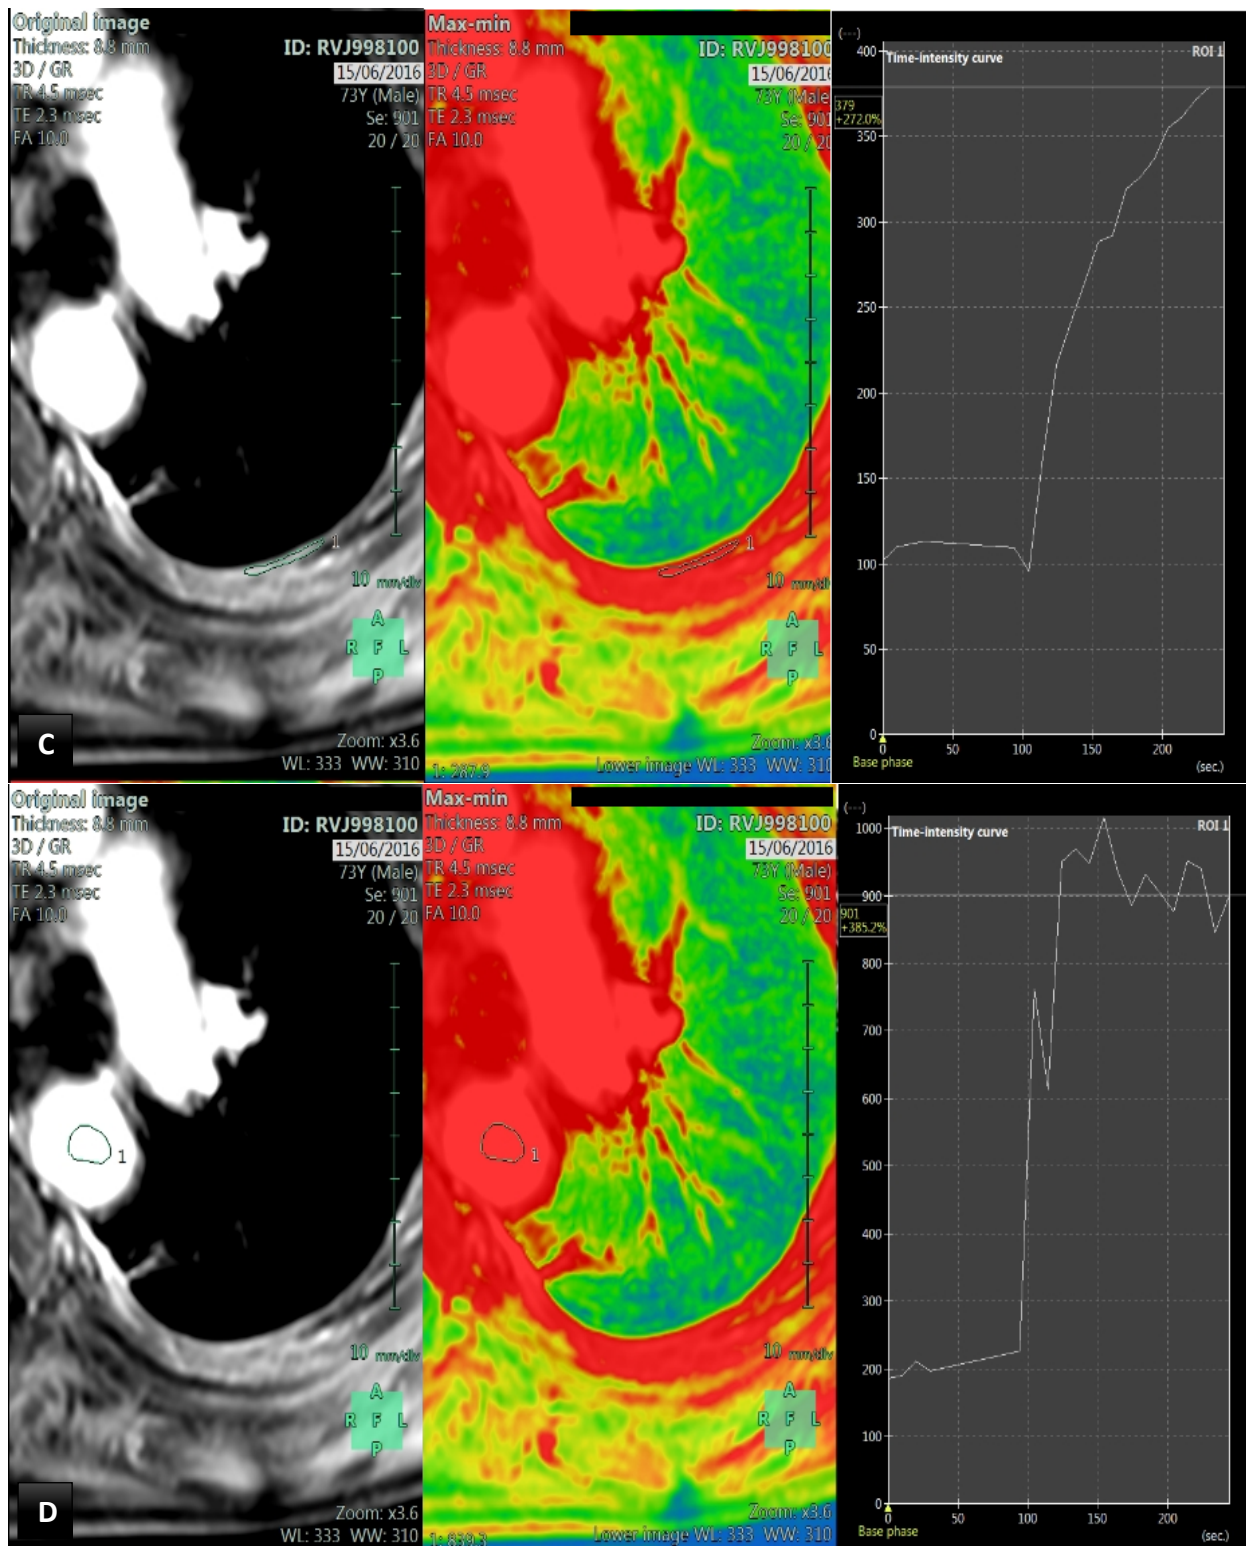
Axial contrast enhanced fat-suppressed T1 weighted MRI images for patient M2. Image C showing the 3rd region of interest drawn around the pleura with the corresponding time intensity curve. Image D shows the region of interest drawn in the aorta which is then used for standardising the raw data (discussed below).
